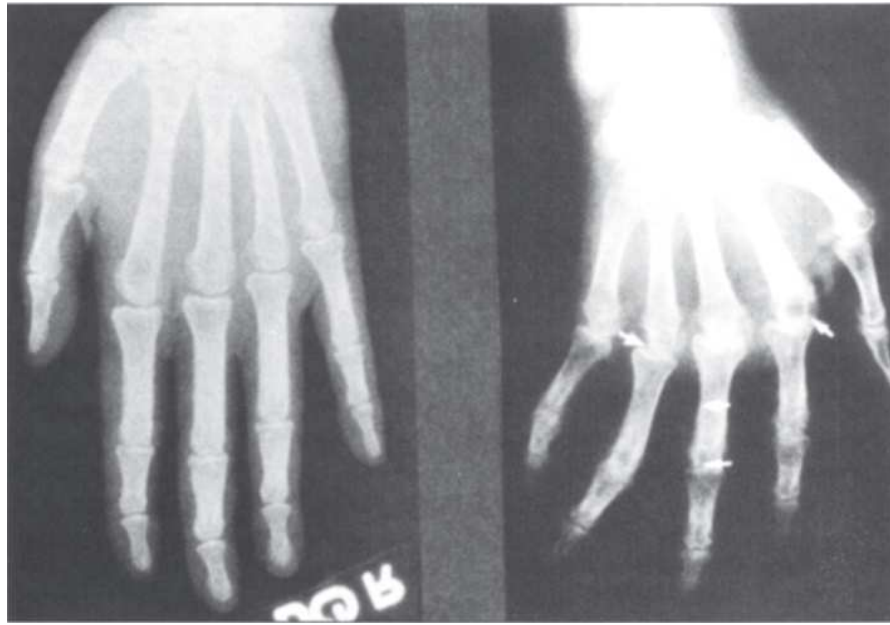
Radiographs of normal hand (left) and arthritic hand (right). (Arrows denote loss of normal axial alignment) (Rhodes, 1991)
